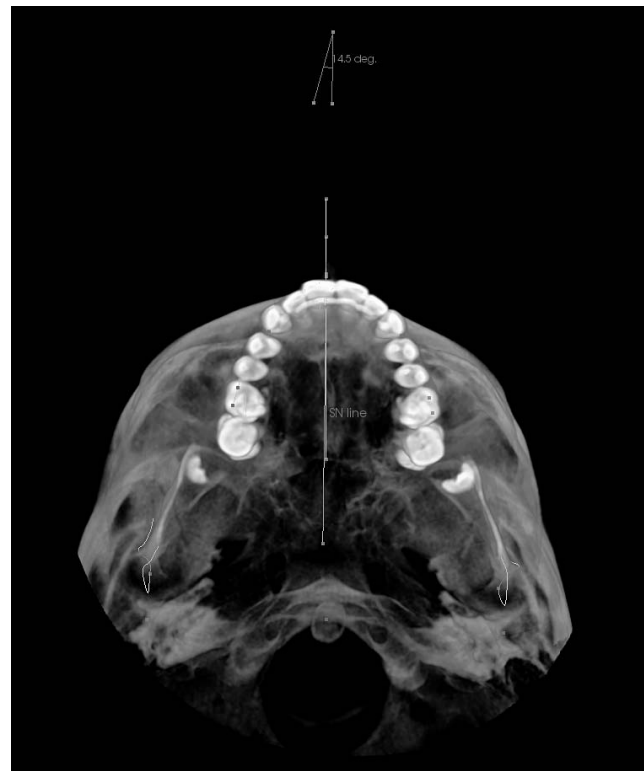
Cone beam computed tomography analysis in the transverse dimension.
